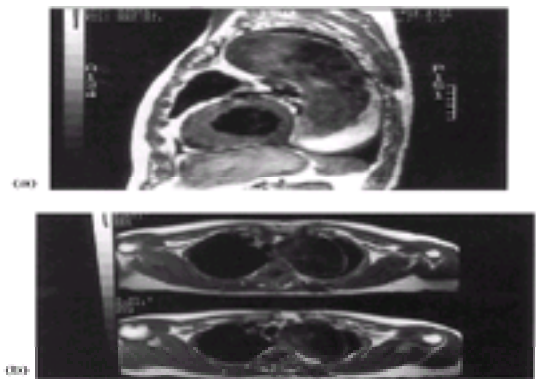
(a) MRI scan of a massive, syphilitic, descending aortic aneurysm;(b) the aneurysmal ascending aorta had already been replaced for rupture.
